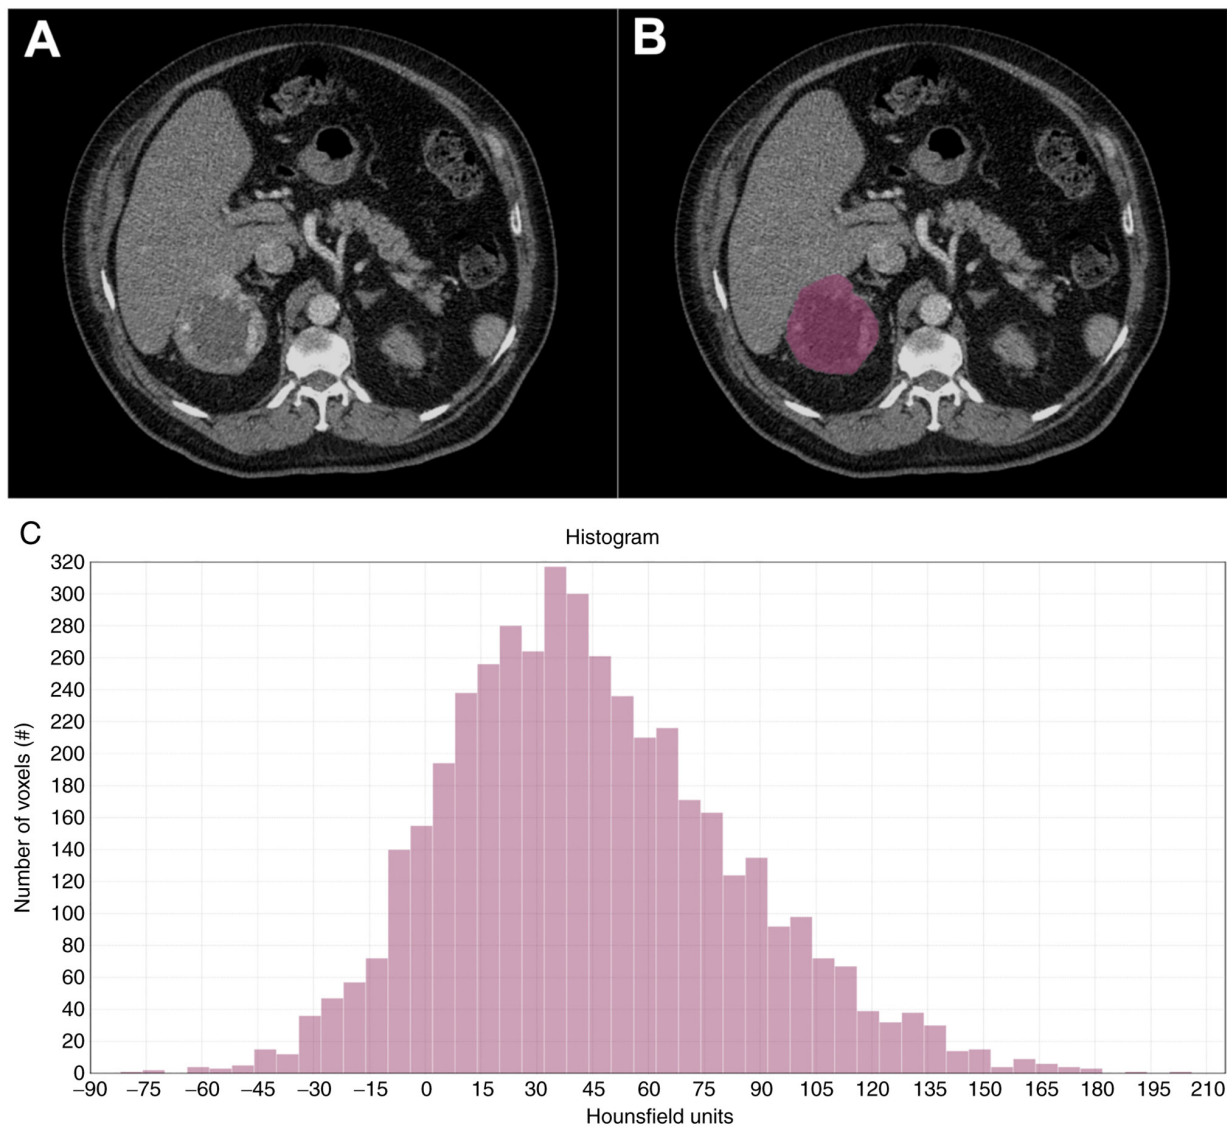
Texture analysis process. (A) Computed tomography abdomen with contrast in arterial phase and (B) region of interest selection. (C) Histogram showing the distribution of Hounsfield Units.
